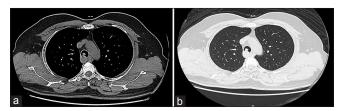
Axial cuts of computed tomography scan thorax mediastinal (a) and lung (b) window demonstrating posterior mediastinal mass invading trachea with intraluminal extension
